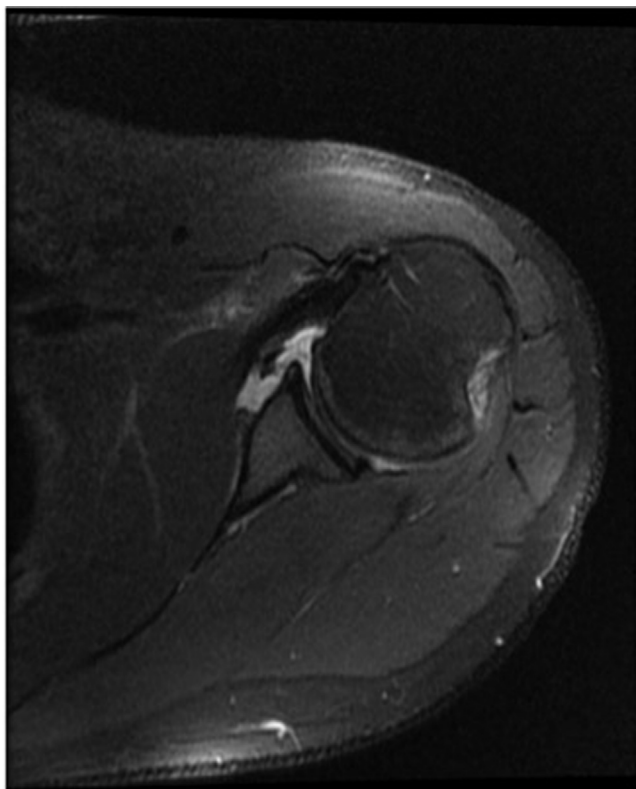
Axial cut of a magnetic resonance imaging of the left shoulder demonstrating a Hill-Sachs lesion with edema.
